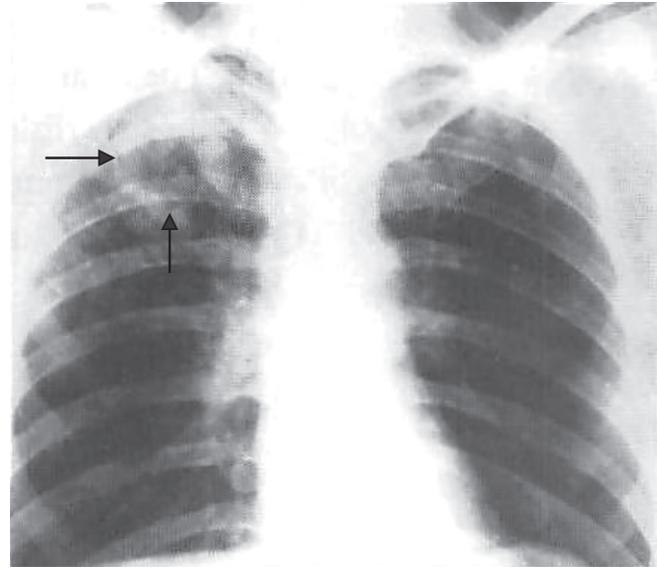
Chest X-ray (PA view) showing a cavity with fibrosis
